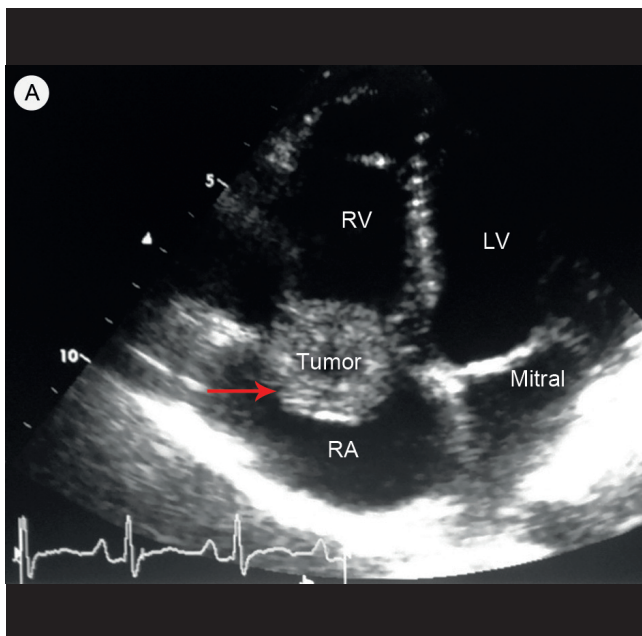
Transthoracic (TTE) and transesophageal (TEE) echocardiographic examinations show a mass in the right heart.
